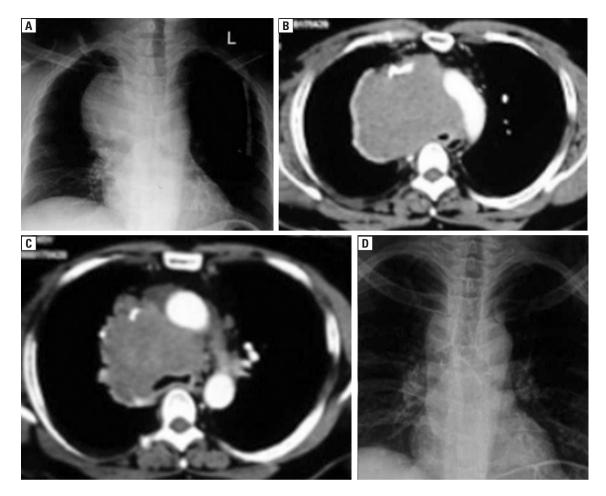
A. Baseline chest radiograph showing a large right paratracheal mass with tracheal compression; B. and C. CT thorax (mediastinal window) demonstrating a large mediastinal mass causing compression of the lower trachea and proximal main bronchi; D. Chest radiograph following chemotherapy showing reduction in the size of the right paratracheal opacity with clearly visible tracheal and both main bronchial lumina
